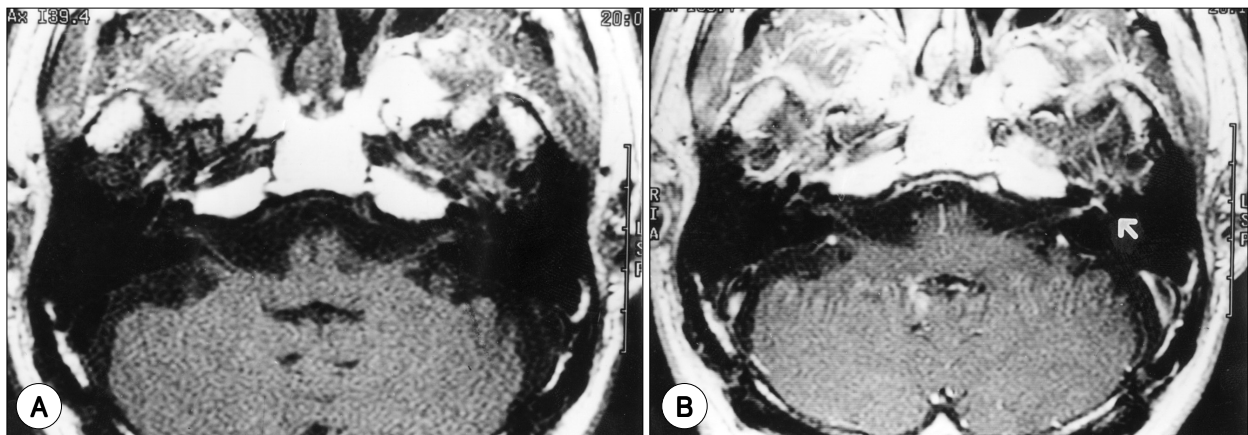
A : Precontrast MRI shows no abnormality. B : Gd-enhanced MRI shows enhancement of the facial nerve from the internal auditory canal to the tympanic segment (white arrow).
